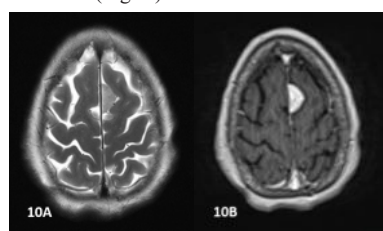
Meningioma: Axial T2W(A) and T1W post contrast (B) MRI image show well defined homogeneously hyperintense extraaxial lesion along the falx cerebri with intense homogeneous enhancement on post contrast images suggestive of meningioma.
